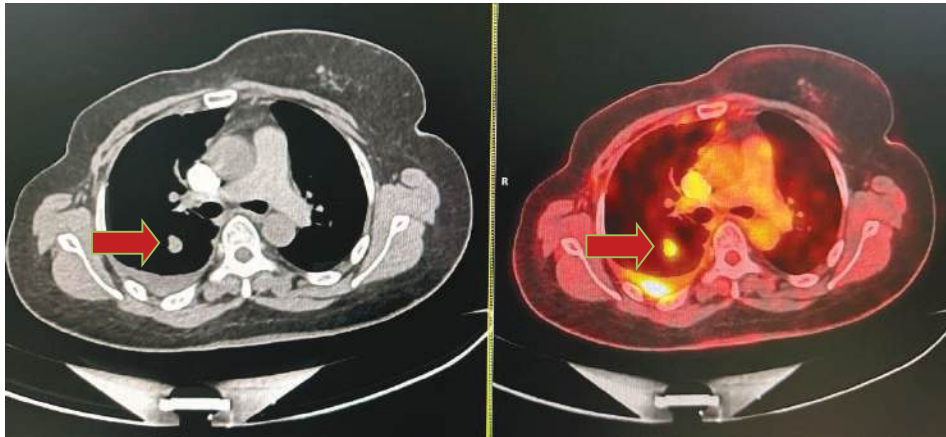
Pulmonary metastases from primary breast cancer in a 56-year-old-woman treated with surgery and NACT. FDG avid (SUV: 5.26) enhancing soft tissue density nodule is seen at the lower lobe of right lung (red arrow). There is right sided malignant pleural effusion.
